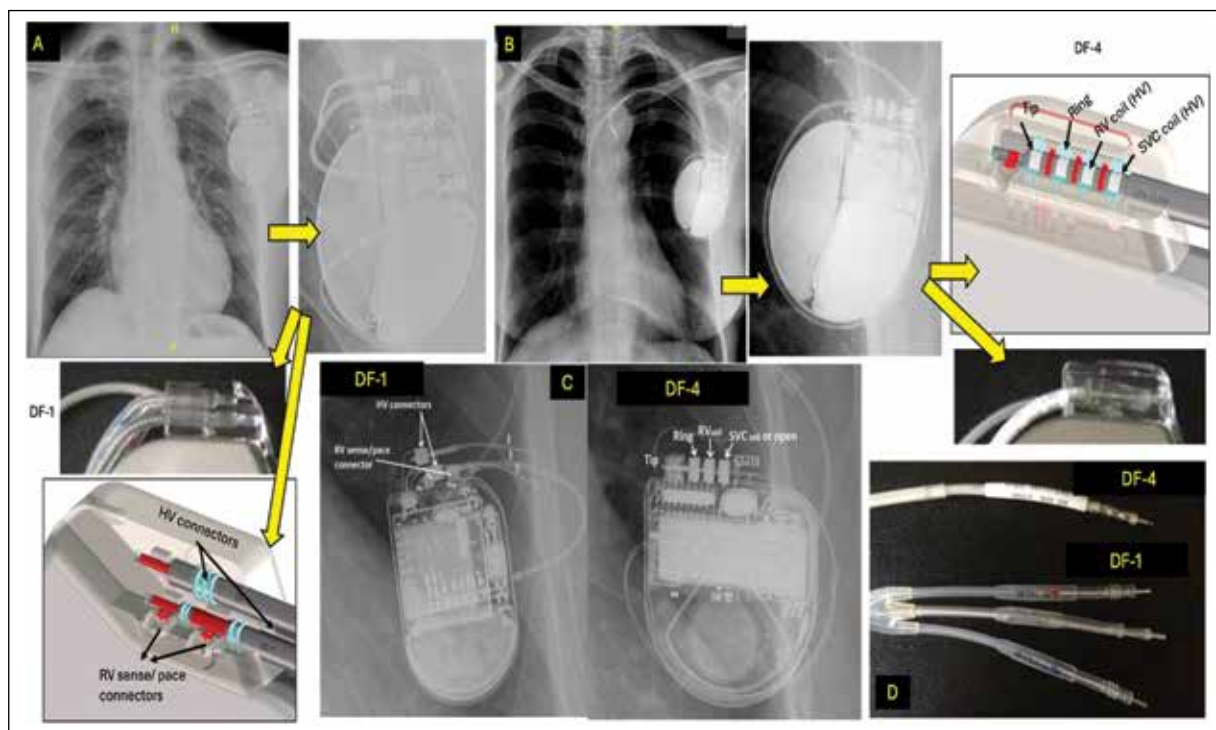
These frontal radiographs show the different defibrillator pulse generator models: a typical Boston Scientific DF-1 pulse generator with separate ports for pacing, sensing, and high energy (A) and another Boston Scientific DF-4 pulse generator with a single common connector for pacing, sensing, and defibrillation (B). Respective insets show a zoomed view and the pulse generator's typical physical appearance and connections. Annotated typical DF-1 SJM system and Medtronic DF-4 system seen (C). Typical DF-1 and DF-4 leads are shown (D).
